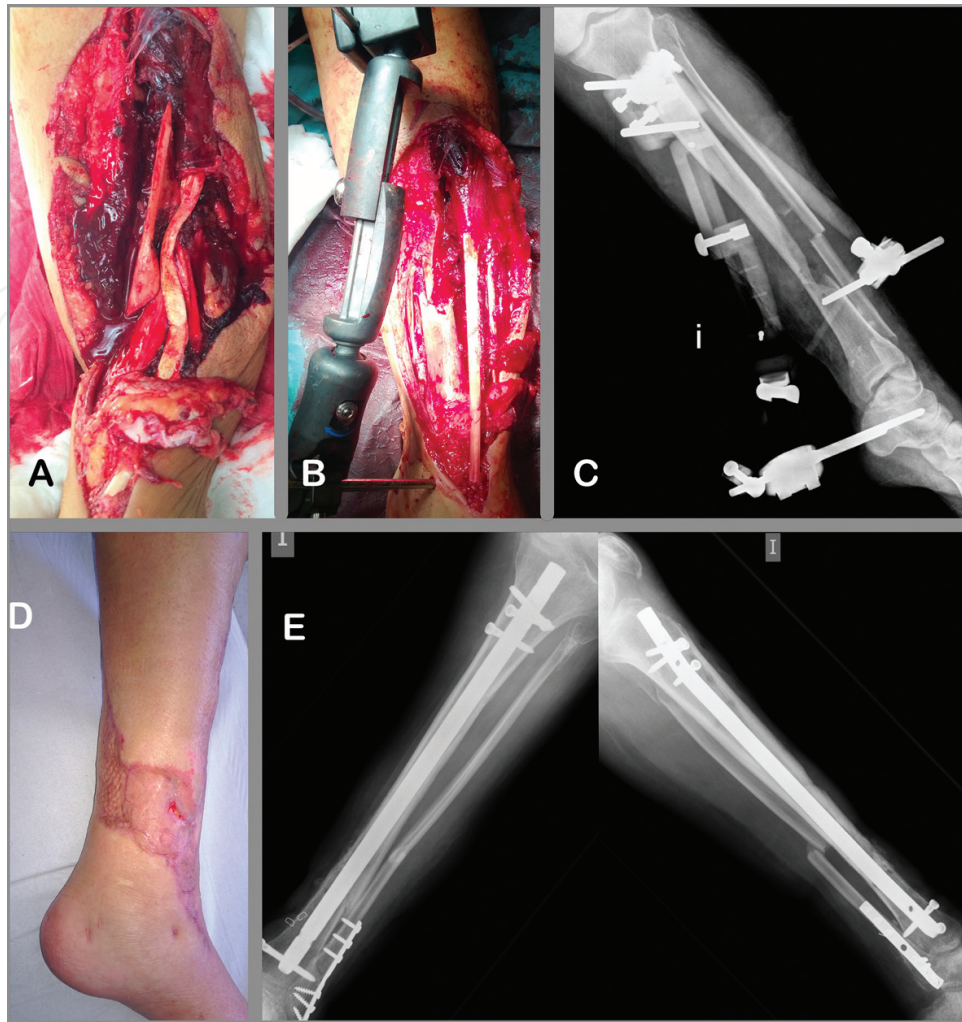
A complete reconstructive procedure in an open fracture grade IIIB tibial fracture, in a 43-year-old female. Image A: photograph in the emergency department of a grade IIIB open fracture in the emergency department. Image B: photograph in the operative theater, temporary fixation of the fracture with an external fixation. Image C: X-ray of the temporarily stabilized fracture with an external fixator, after soft-tissue and bone debridement. Image D: the final soft tissue coverage of the injury. Image E: an anteroposterior and lateral X-ray, after definitive fixation of the fracture with a nail.
